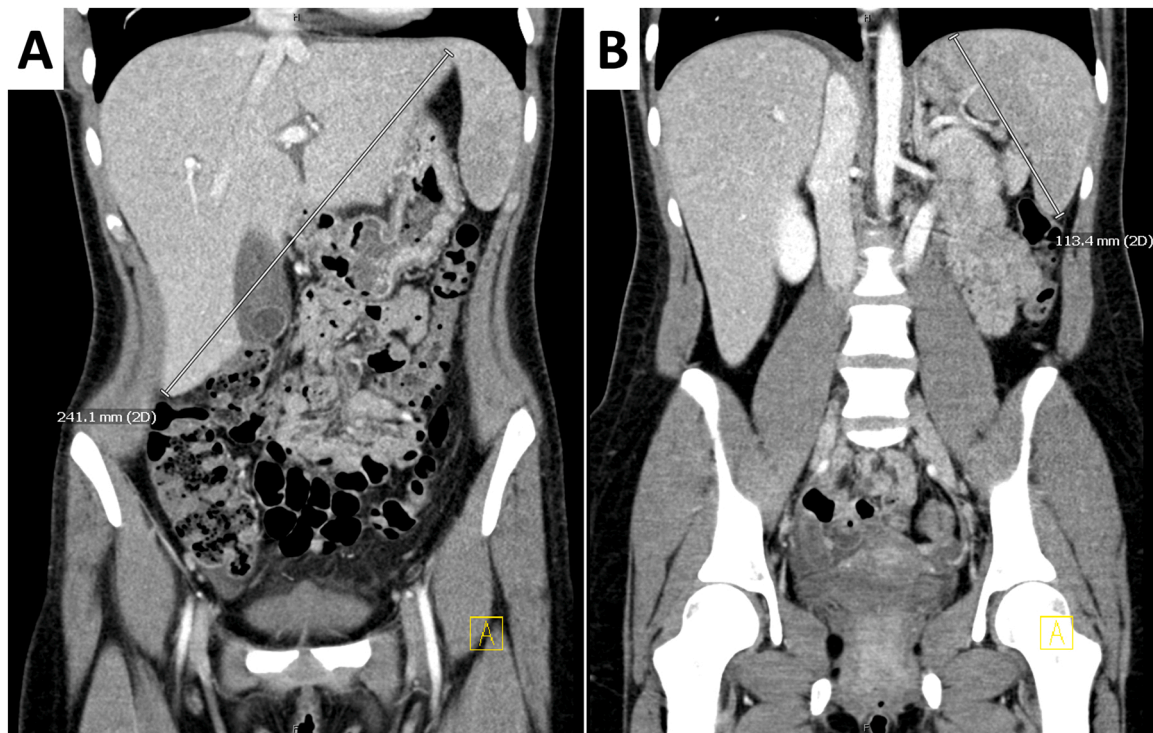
Contrast enhanced CT scan of the abdomen and pelvis. (A) Hepatomegaly with subtle heterogeneous enhancement and moderate periportal edema, moderate gallbladder wall thickening without evidence of gallstones or inflammatory changes and no biliary ductal dilatation. (B) Moderate splenomegaly with rounded configuration of the spleen with heterogeneous enhancement with mottled lucency.
